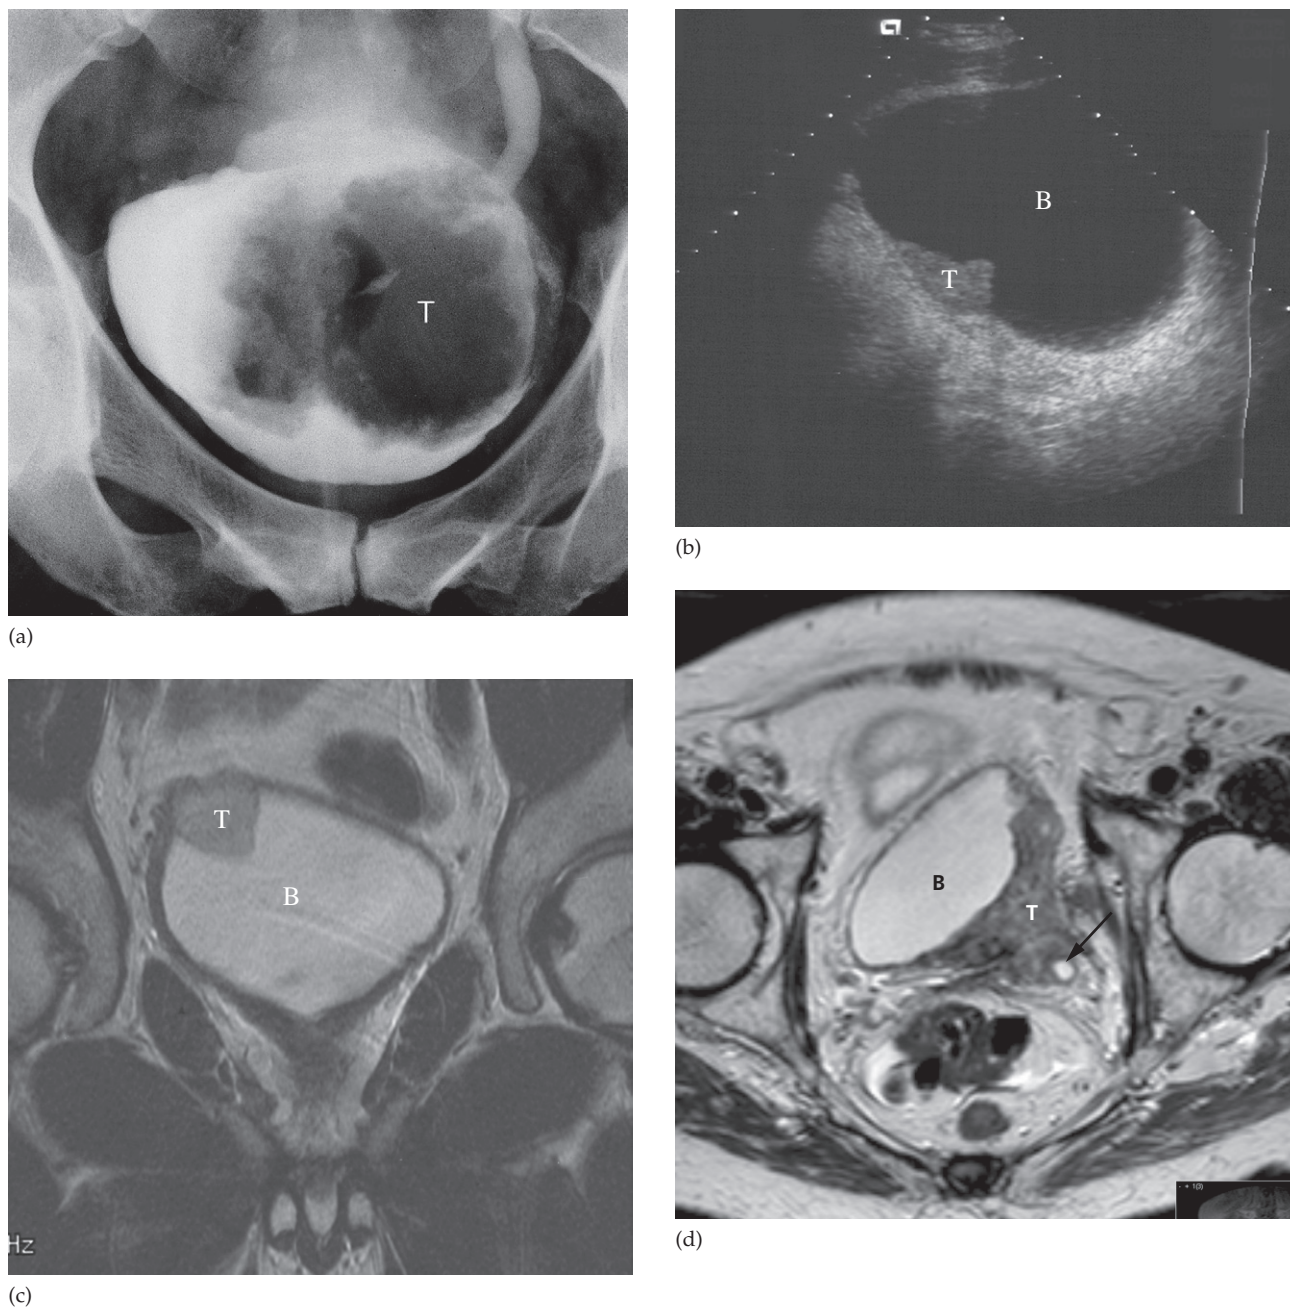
Bladder neoplasm. (a) There is a large filling defect in the left side of the bladder from a transitional cell carcinoma. Note the obstructive dilatation of the left ureter. (b) Ultrasound scan from a different patient showing a small tumour within the bladder. (c) T2-weighted coronal MRI of the bladder tumour seen on ultrasound in (b). (d) Advanced stage bladder tumour arising from the left bladder wall and extending into the perivesical fat. Note the obstructed left ureter (arrow). B, bladder; T, tumour.
